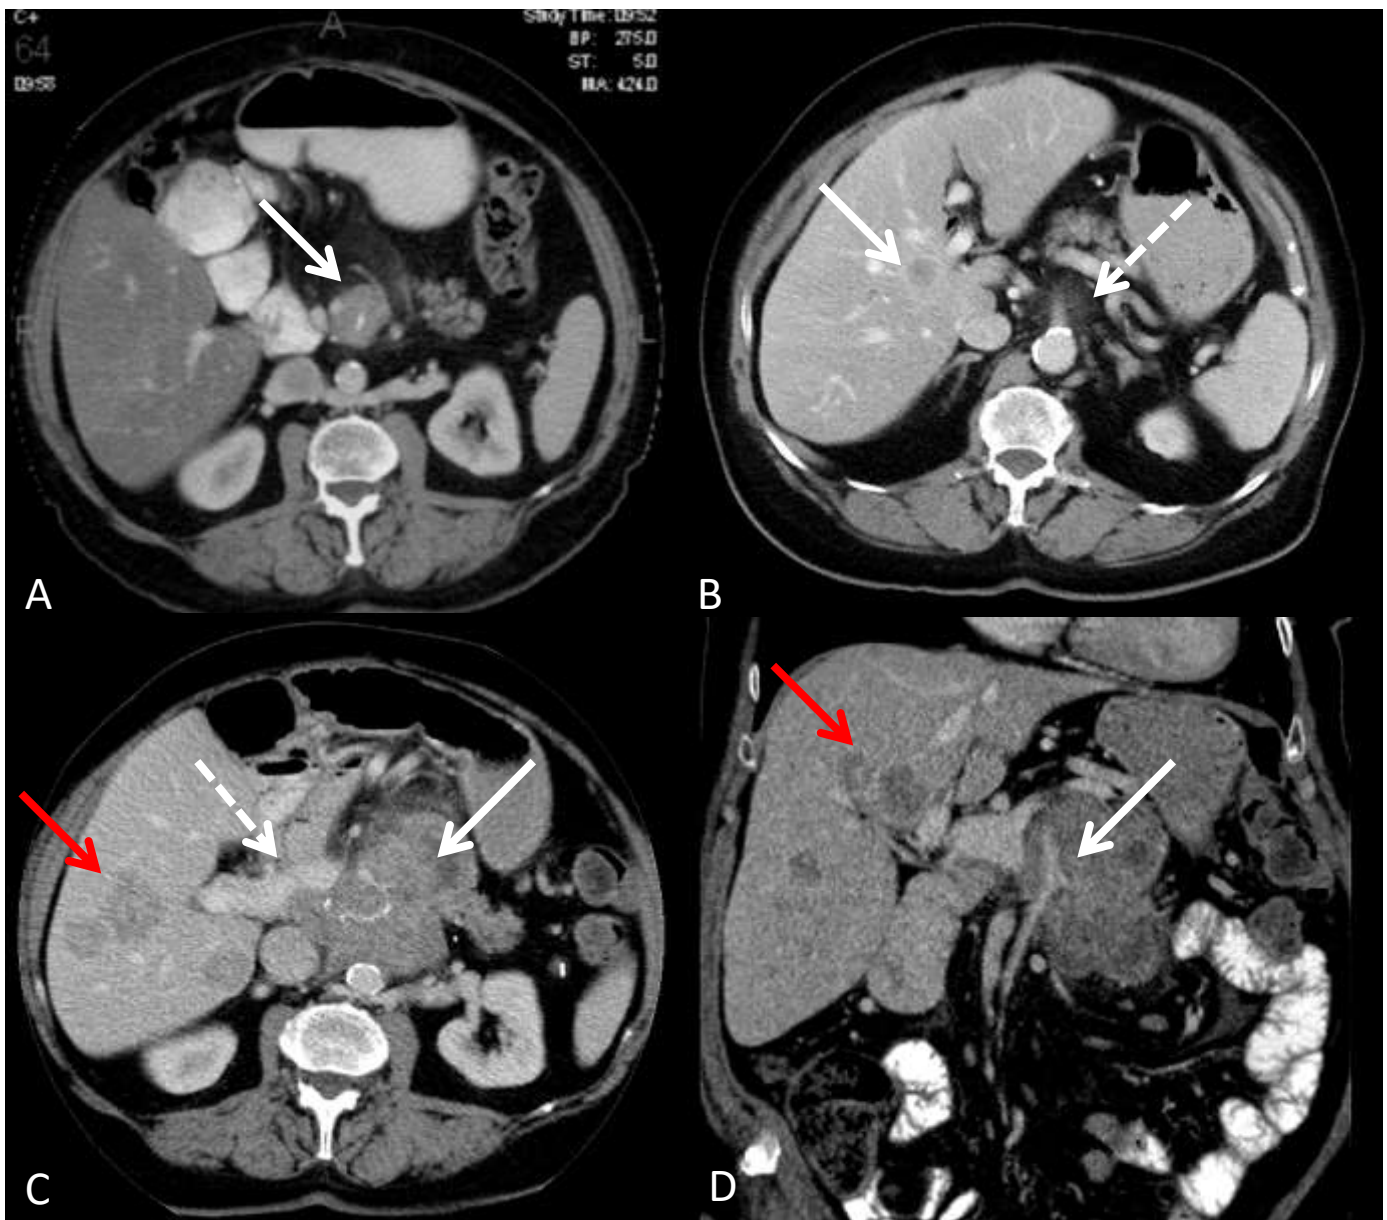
Radiographic progression of serous cystic tumor over 17-year surveillance.
